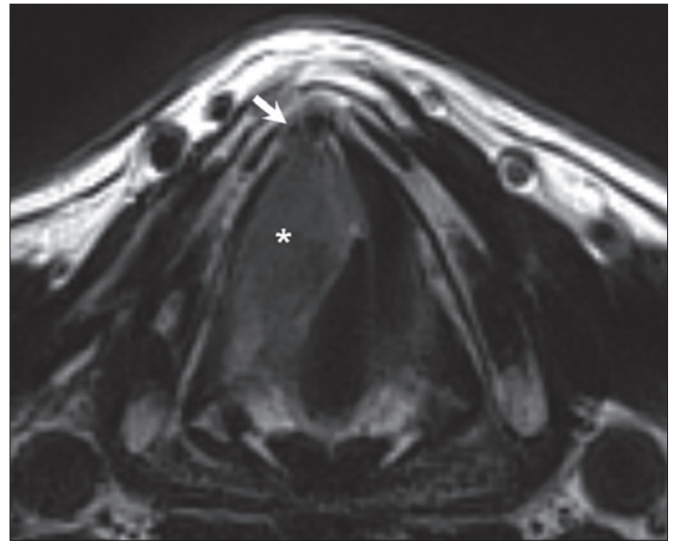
T2-weighted image (left top), apparent diffusion coefficient (ADC) map (right top), unenhanced T1-weighted (left bottom), contrast-enhanced T1-weighted (right bottom). Images show a submucosal recurrence infiltrating thyroid laminae (asterisks). The signal pattern of cartilage-infiltrating tumour includes T2 intermediate signal, low ADC value, low T1 signal before contrast injection and contrast-enhancement. Arrows show a part of right thyroid lamina with a signal pattern consistent with chondritis: T2 hyperintensity, high ADC value, low T1 signal before contrast and intense contrast-enhancement.
